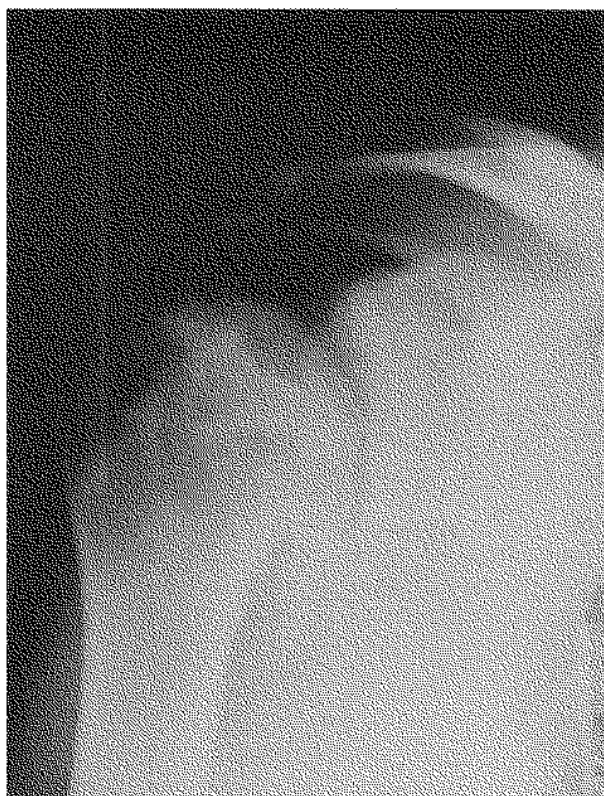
a) Anteroposterior roentgenogram taken 3 years after injury shows a thin radiotransparent halo on the superomedial edge of the humeral head compatible with osteonecrosis.
